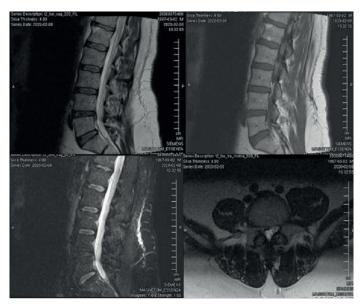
Preoperative sagittal and axial lumbar MRI images of a 32-year-old female patient with CNS-positive aerobic disc culture
